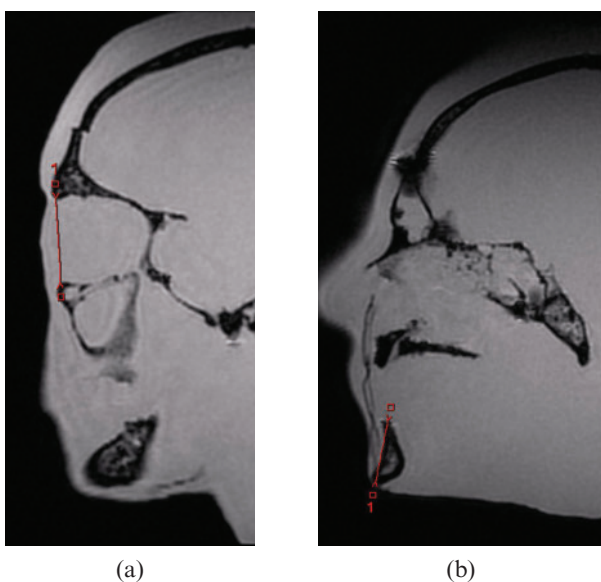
Black bone MRI measurements: (a) orbit, (b) mandible height.
